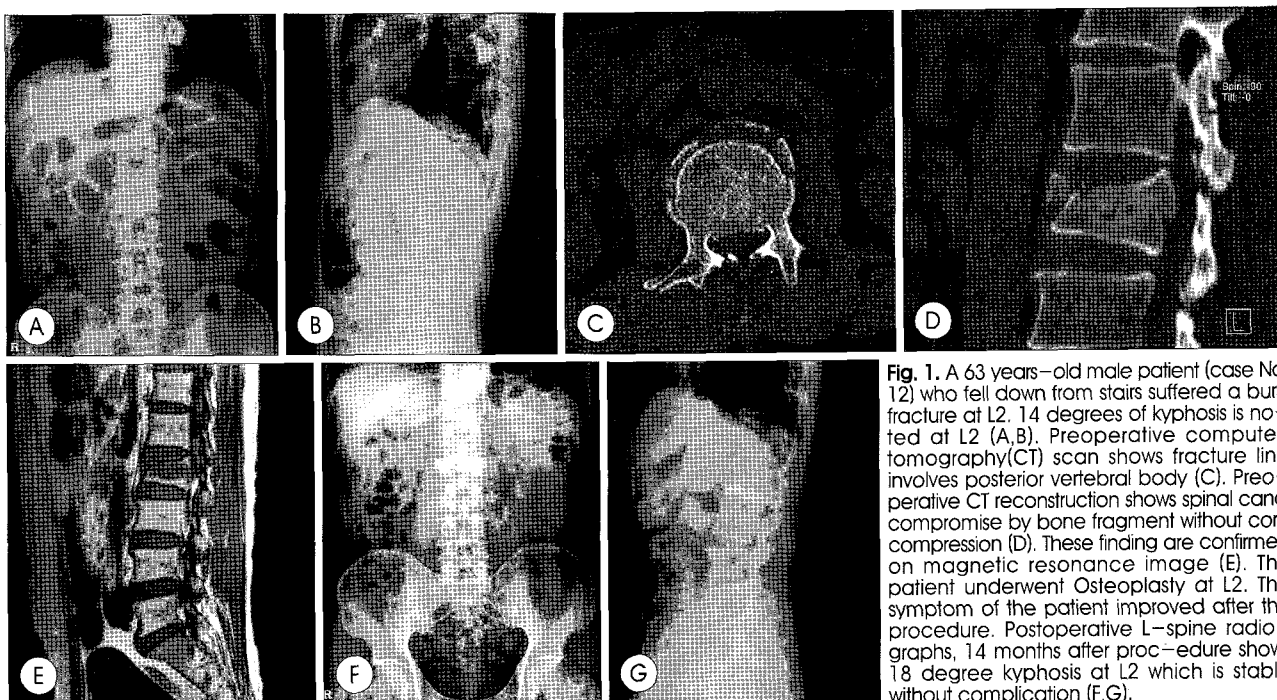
A 63 years-old male patient (case No. 12) who fell down from stairs suffered a burst fracture at L2. 14 degrees of kyphosis is noted at L2 (A, B). Preoperative computed tomography(CT) scan shows fracture line involves posterior vertebral body (C). Preoperative CT reconstruction shows spinal canal compromise by bone fragment without cord compression (D). These findings are confirmed on magnetic resonance image (E). The patient underwent Osteoplasty at L2. The symptom of the patient improved after the procedure. Postoperative L-spine radiographs, 14 months after procedure shows 18 degree kyphosis at L2 which is stable without complication (F, G).
